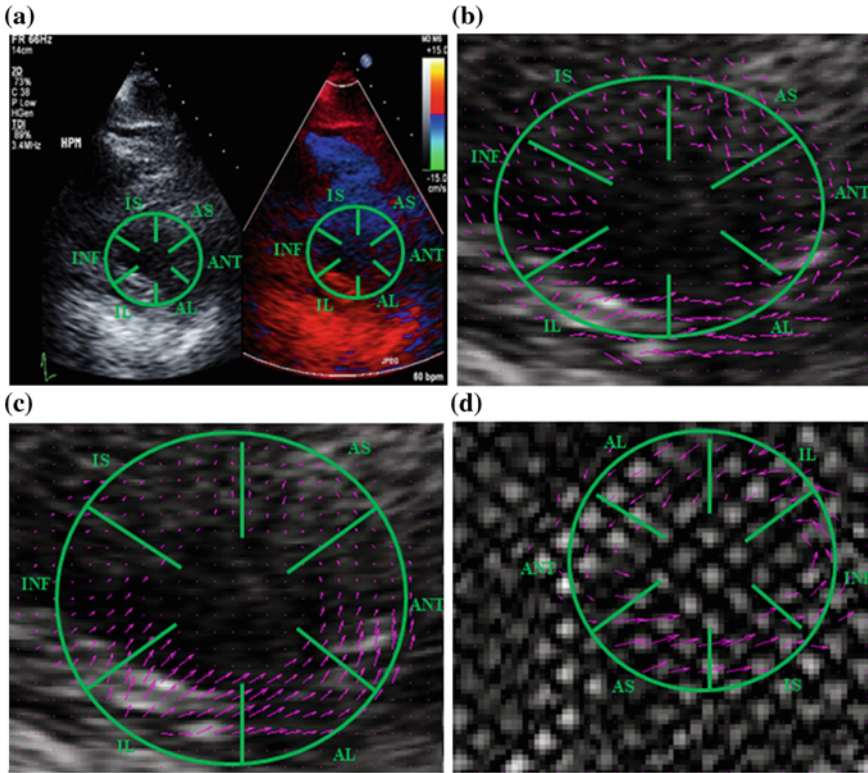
a A short axis B-mode image at the high papillary muscle level of a subject during early systole compared to TDI image for the same phase. b Horn-Schunck motion field for the same phase and in the same subject as a. c Corresponding TDIOF motion field. d Tagged MRI motion field for the same approximate slice location in systole (*AS* antero-septal, *ANT* anterior, *IL* infero-lateral, *AL* antero-lateral, *P* posterior, *INF* inferior, *IS* infero-septal)
